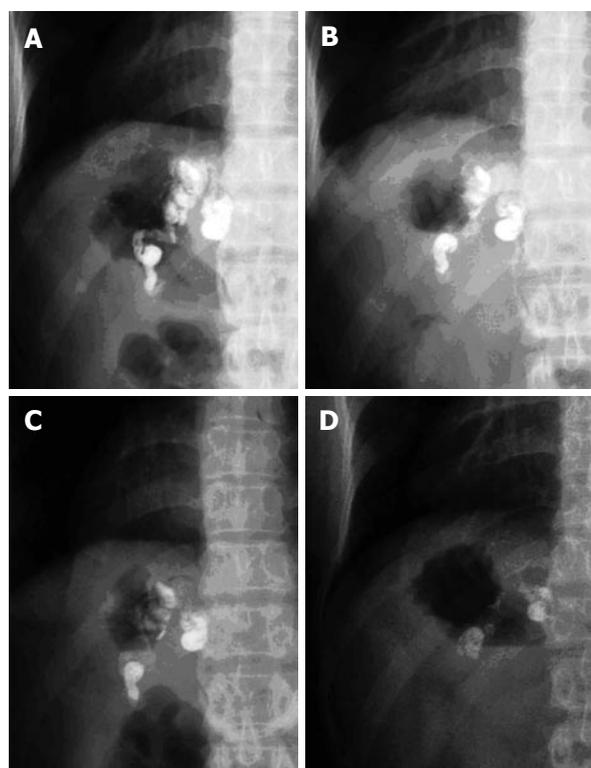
This 47-year-old female patient has isolated gastric varices. Expulsion of tissue glue on X-ray view. A: One day after injection; B: Two weeks after injection; C: One month after injection; D: Three months after injection. Lipiodol mass (intravascular) was in the stomach only and became smaller gradually. This indicated the extrusion process of glue.
